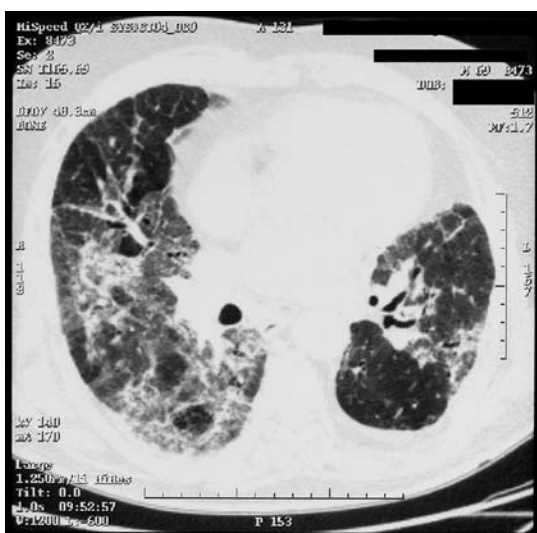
High resolution chest computed tomography (HRCT). Status after partial resection of the left lung. Bilateral interstitial and alveolar opacifications with high-attenuating pleural-parenchymal consolidations and bronchial dilatations characteristic of pulmonary fibrosis
